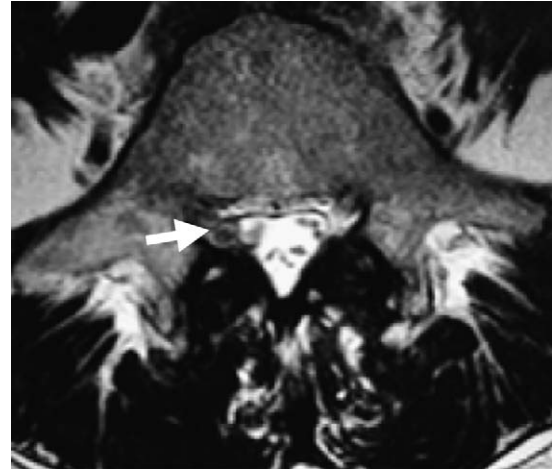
Axial T2-weighted magnetic resonance imaging shows an abnormal signal with double contour (arrow) along the margin of the L5 pedicle in close apposition to the dural sac.
